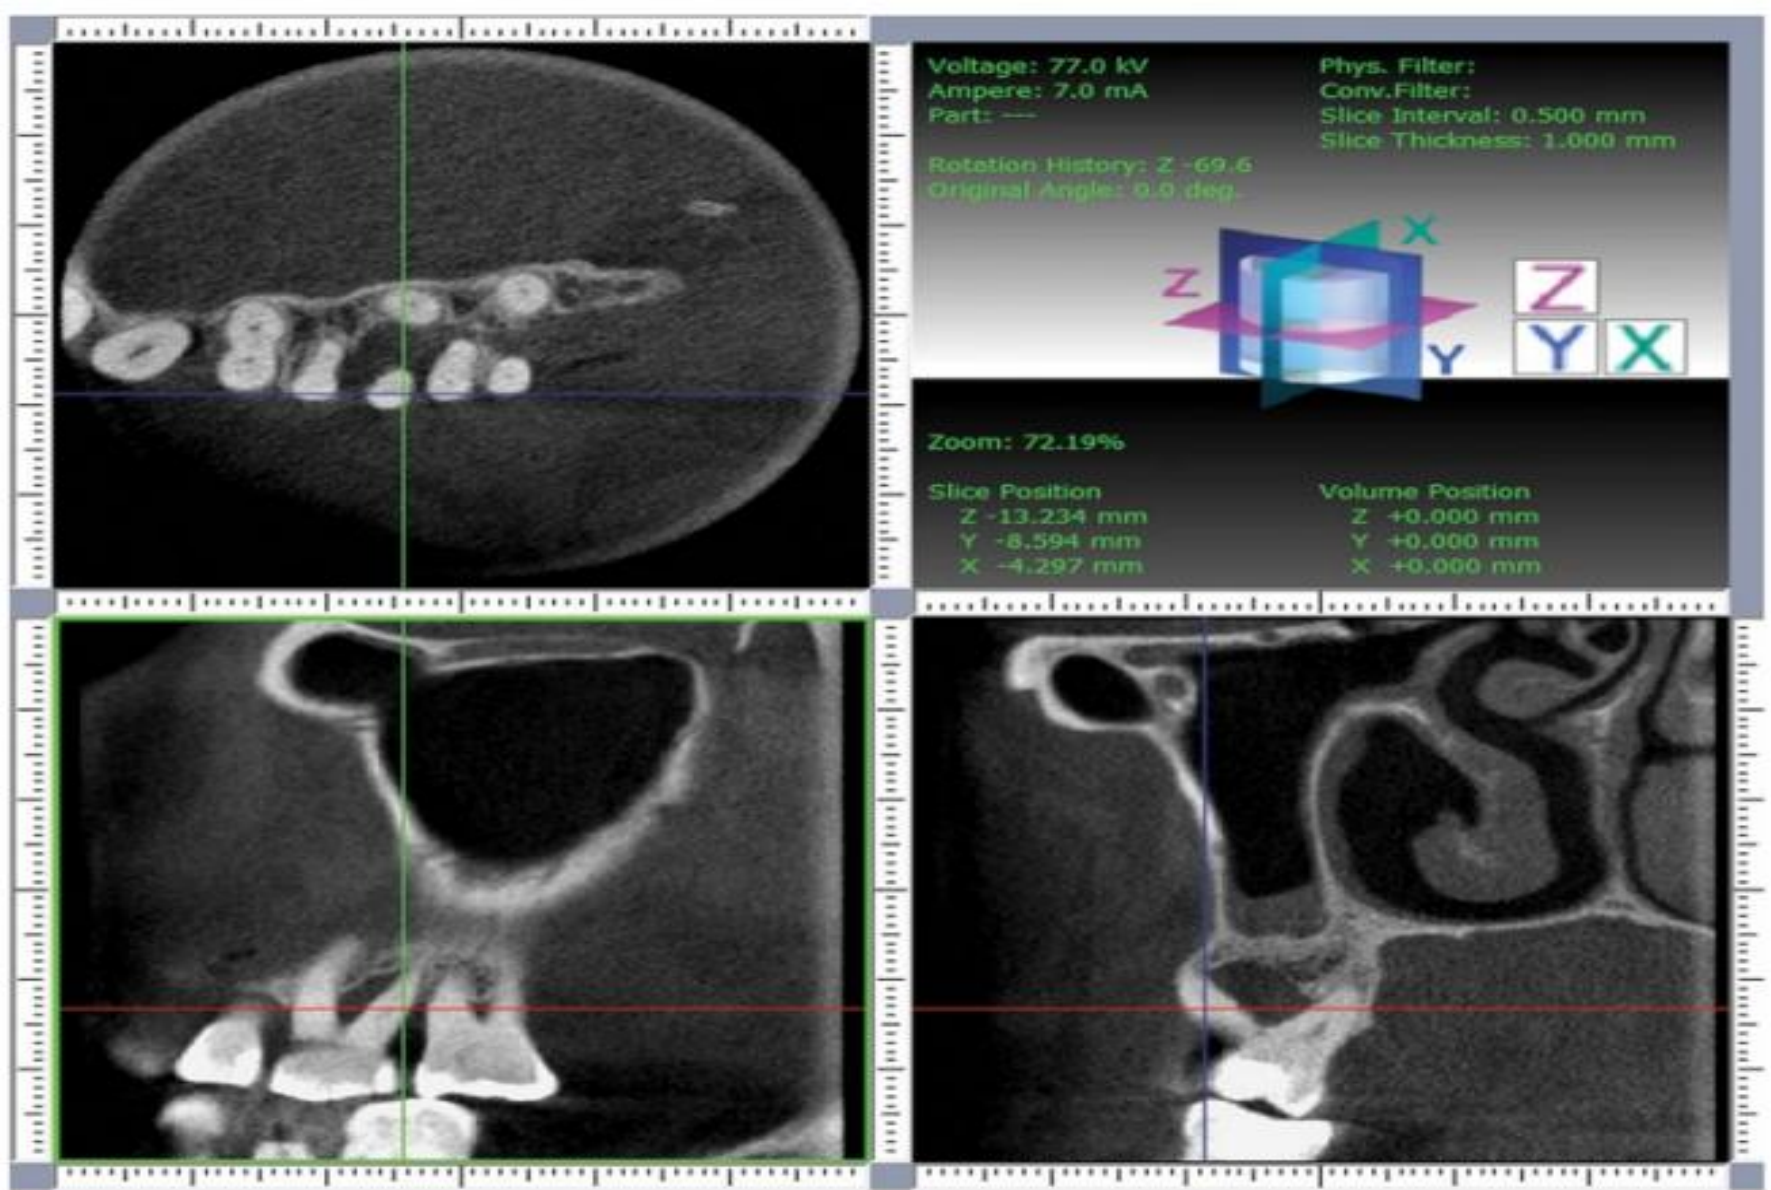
Diagnosis and treatment planning using cone-beam computed tomography (CBCT). CBCT images with horizontal, sagittal, and transversal sections of first and second left maxillary molars. According to the bone loss around the disto-buccal root and the remaining periodontal attachment around the mesio-buccal and palatal root, it was decided to extract the distobuccal root. *Source:* Walter et al. (2010).
